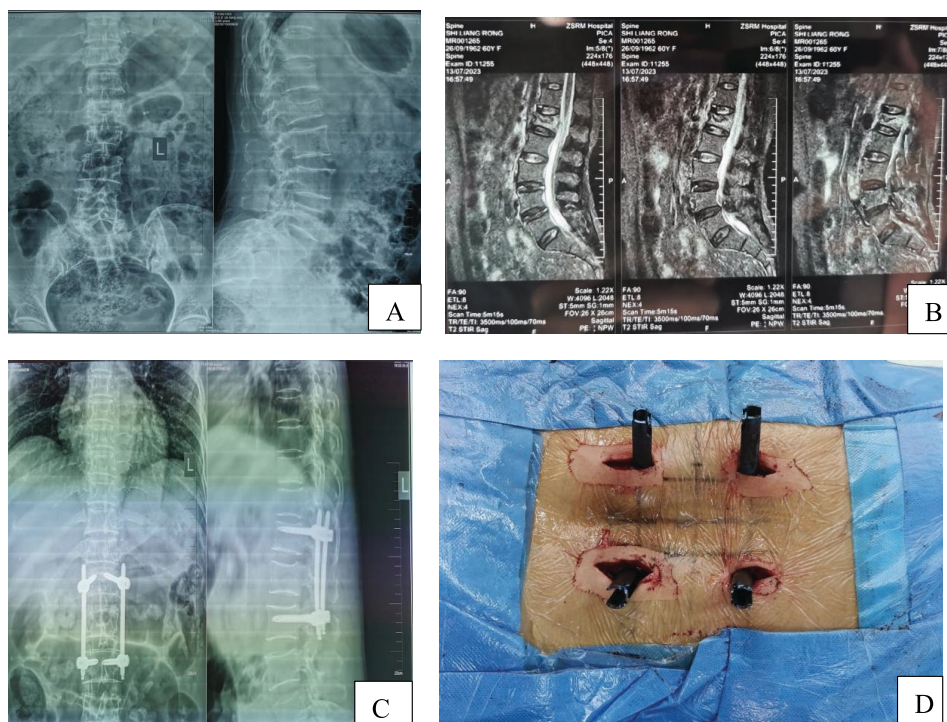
Percutaneous pedicle screw treatment of lumbar fractures. (A) Preoperative X-ray (B) Pre-operative MRI (C) Post-operative X-ray (D) Percutaneous pedicle screw implantation
